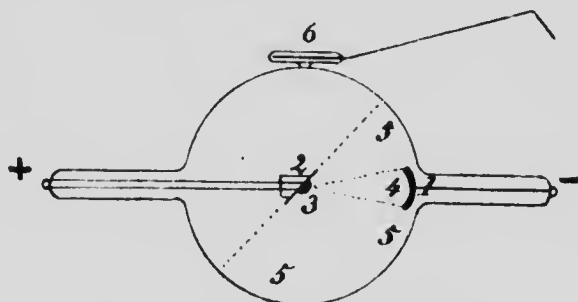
ORDINARY X-RAY TUBE.
